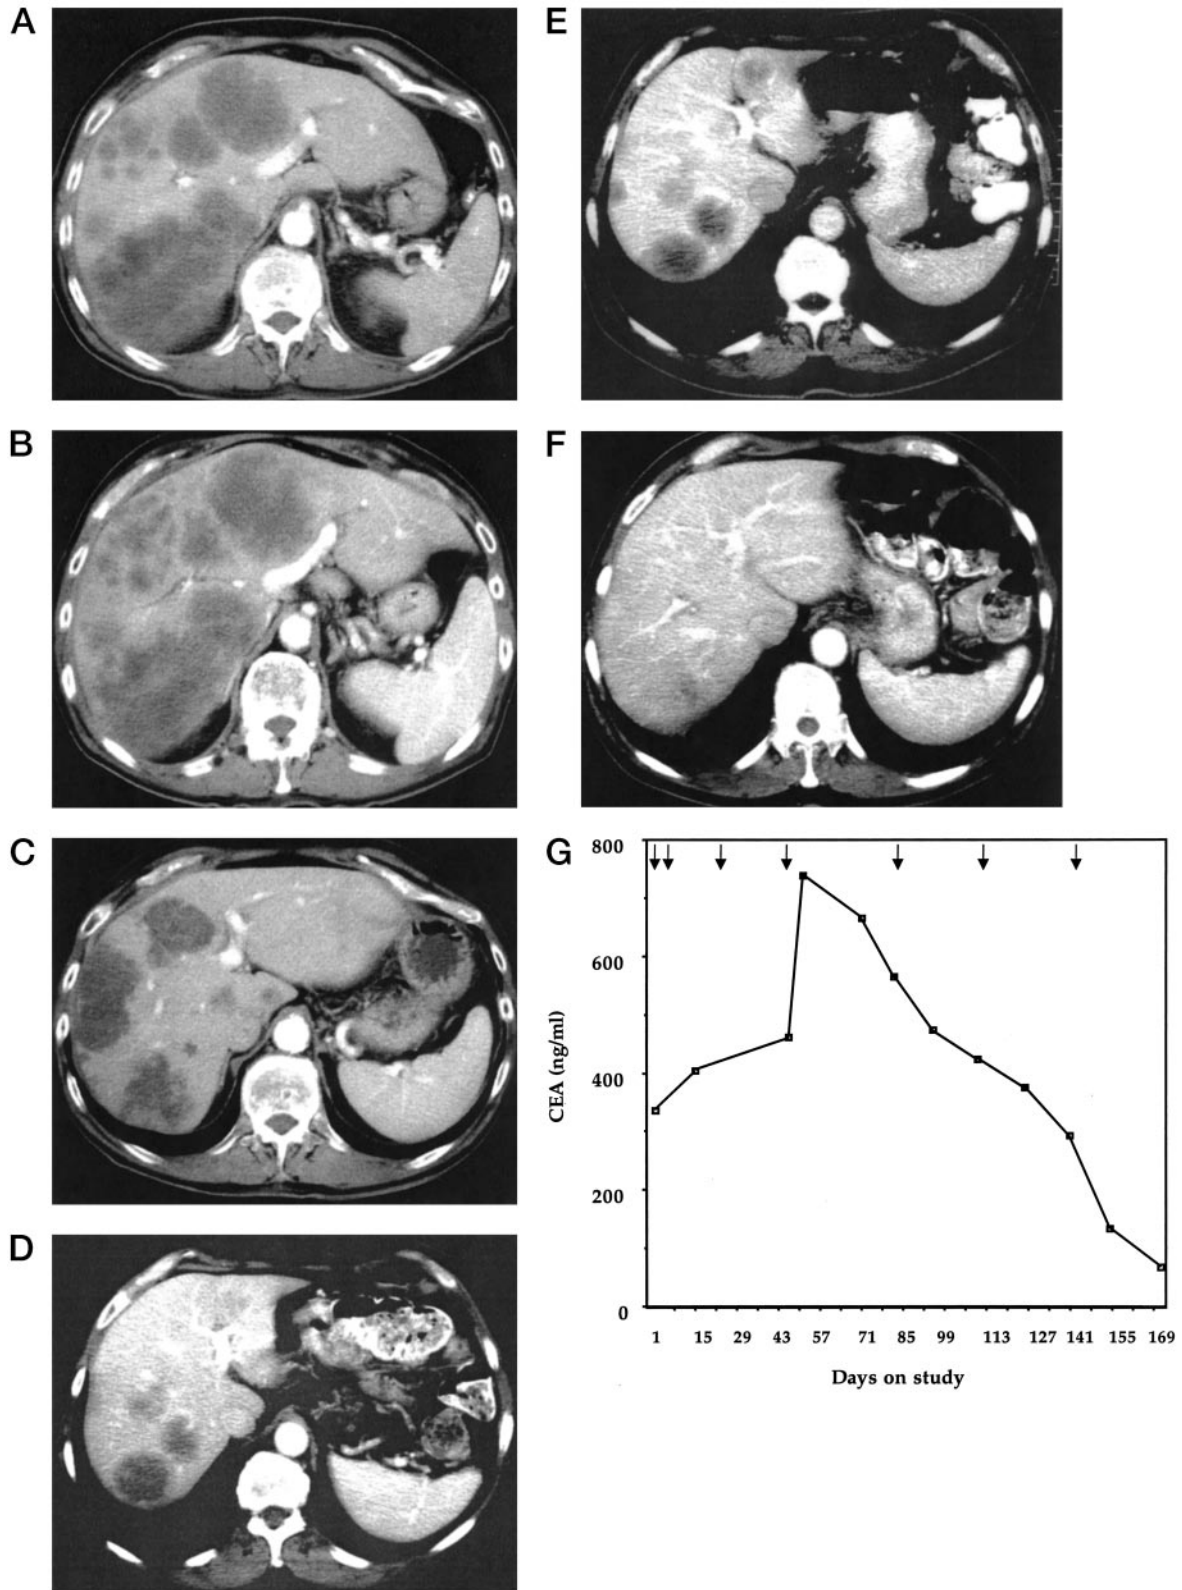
Early and delayed radiographic and tumor marker changes in patients with metastatic colon cancer. Serial contrast-enhanced CT scans at the level of the left portal vein from 3 patients are shown. Patient 3006 had previously untreated metastatic colon cancer to the liver at the time of study entry (A). After two cycles of single agent *dl1520* the tumor masses were notable for acute swelling (B). After combination treatment with *dl1520* plus chemotherapy (C), the overall tumor cross-section has decreased by >50% and the vascularity of the residual masses is markedly reduced (consistent with necrosis). Patient 3005 had metastatic colon cancer that was treated previously with three cycles of 5-FU/leucovorin. Nine months later the patient presented with tumor progression (D). After two cycles of single agent *dl1520* (E), the largest tumor mass was notable for acute swelling and decreased vascularity (consistent with necrosis). After combination treatment with *dl1520* plus 5-FU/leucovorin (F), near complete disappearance of the tumor masses was demonstrated. G, patient 3013 presented with a rapidly progressive CEA level and 5-FU-refractory colon cancer within the liver after three prior 5-FU-based chemotherapy regimens, including bolus and continuous infusions of 5-FU. After two cycles of single agent *dl1520*, the CEA continued to increase (downward arrows delineate treatment cycles). After the second cycle of combination treatment with *dl1520* plus 5-FU/leucovorin (fourth arrow), a sudden spike in the CEA level was demonstrated; a significant increase in intratumoral necrosis was noted on CT scan at this time. The CEA subsequently decreased significantly over time. Significant necrosis and tumor shrinkage was noted on CT scan during this interval.
